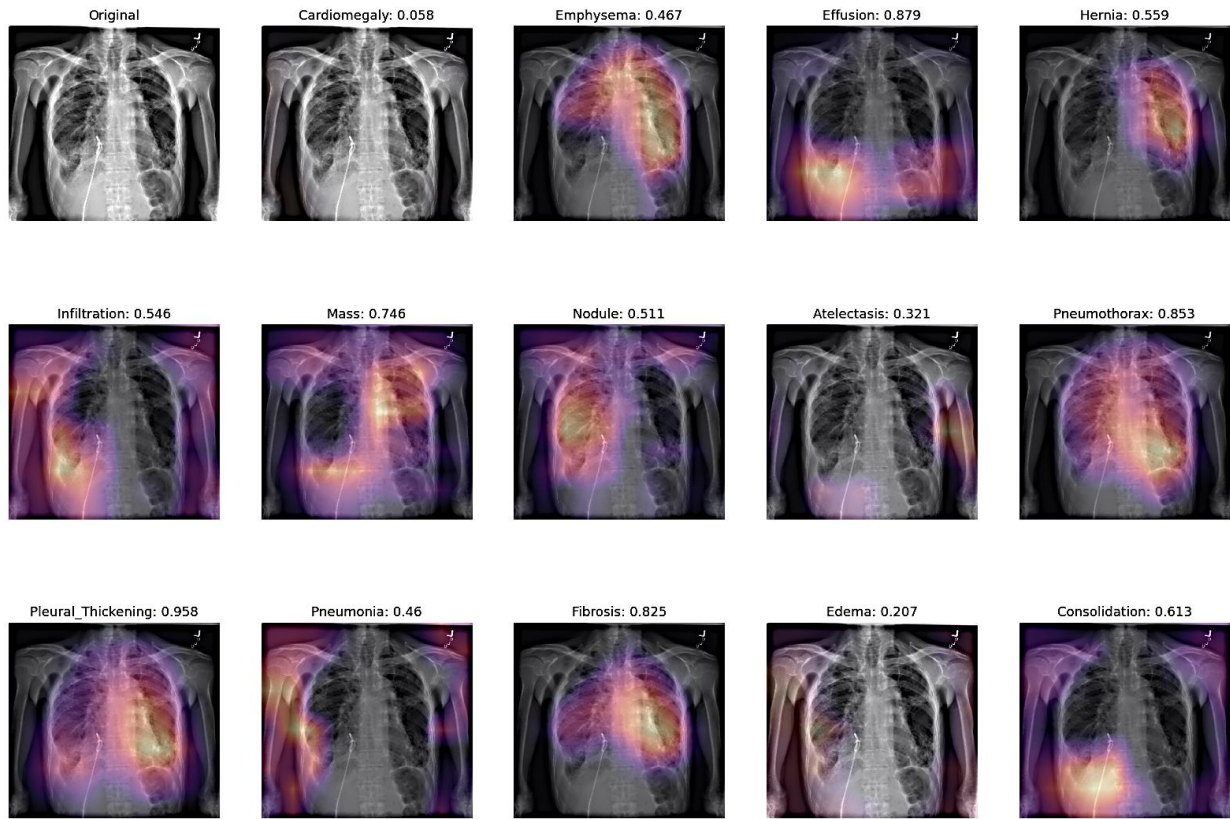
Chest X-ray classification results for low likelihood heart enlargement for Case Study 3
